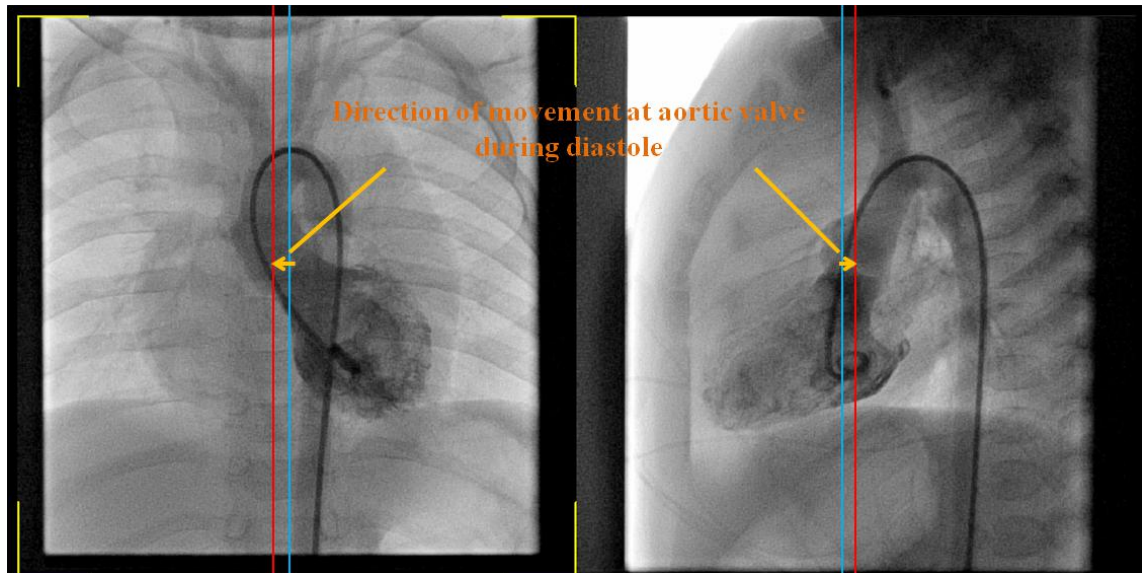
CT image at maximum volume of ventricle (left: front view, right; side view)
